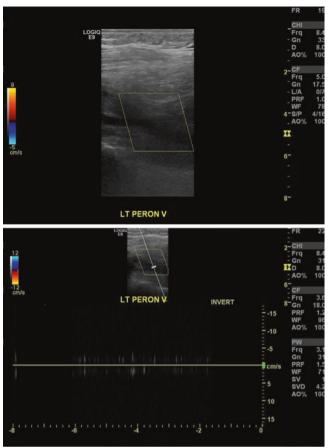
Color Doppler images of the peroneal vein ("distal DVT") demonstrating no color flow (*top image*). Spectral Doppler tracing reveals no waveforms compatible with occlusive thrombus
